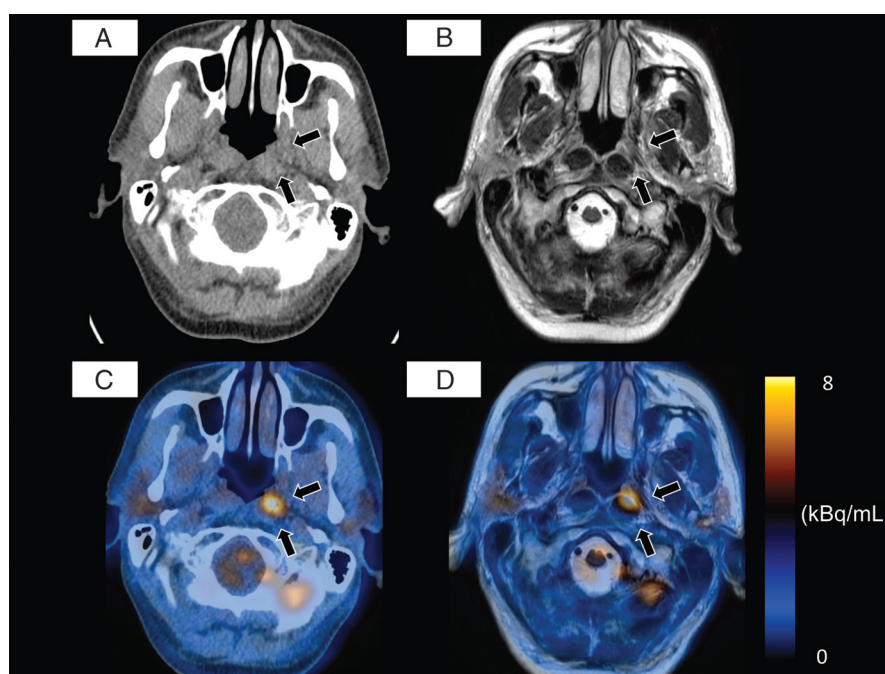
A 57-year-old woman with CUP manifesting as squamous cell carcinoma in cervical lymph nodes. CT image (A), T2-weighted MR image (B), and fused PET images corresponding to images A and B (C and D, respectively) were obtained. Fused images (C and D) show an FDG-avid lesion in the fossa of Rosenmüller (arrows), a place where occult nasopharyngeal carcinoma is sometimes located. On the CT image (A), no anatomical abnormality is seen (arrows); however, ruling out a tumor is difficult. On the MR image (B), mucosa, fat, and muscle tissue are clearly differentiated (arrows), which is helpful to assign the FDG uptake to normal tissue. After the exam, the fossa was verified to be normal by panendoscopy. Especially in the head and neck, physiologic FDG uptake may lead to false positives and may provoke unnecessary biopsy or delay of treatment. Unlike CT, MR provided complementary information for PET in this case.
